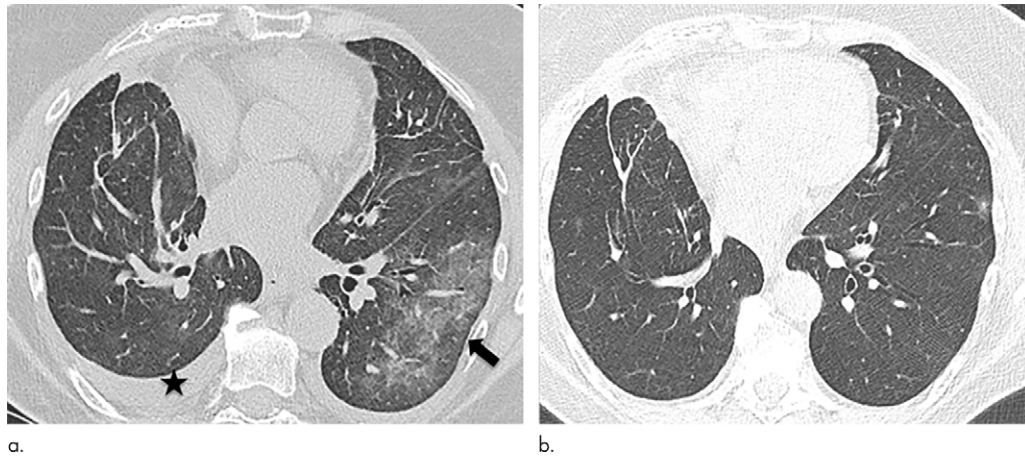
Images in 74-year-old woman with HKU1 coronavirus pneumonia. (a) CT scan performed at admission shows a large area of peripheral ground-glass opacity (arrow) in the lower left lobe and small pleural effusions (star). (b) The CT scan performed after 14 days shows almost complete resolution of the imaging findings.
